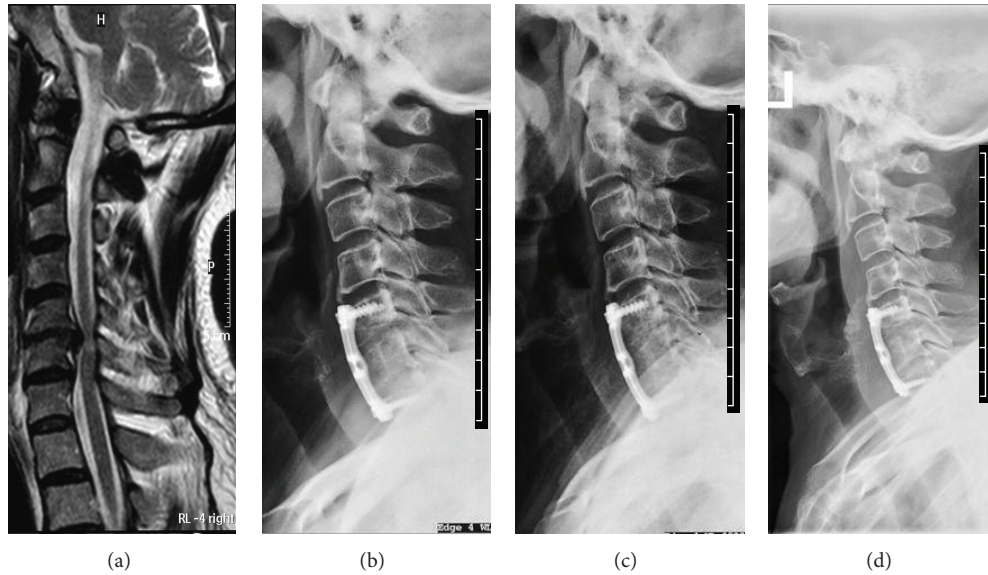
A 67-year-old man underwent cervical corpectomy and fusion with an n-HA/PA 66 mesh cage for CSM. (a) The compression located in the C6 level on the preoperative cervical MRI. (b) Lateral radiograph immediately after surgery. (c) 3 months after surgery. (d) Two years after surgery. The fusion status cannot be identified on the lateral radiograph, but cervical alignment, plate, and screws were not changed during follow-up.
